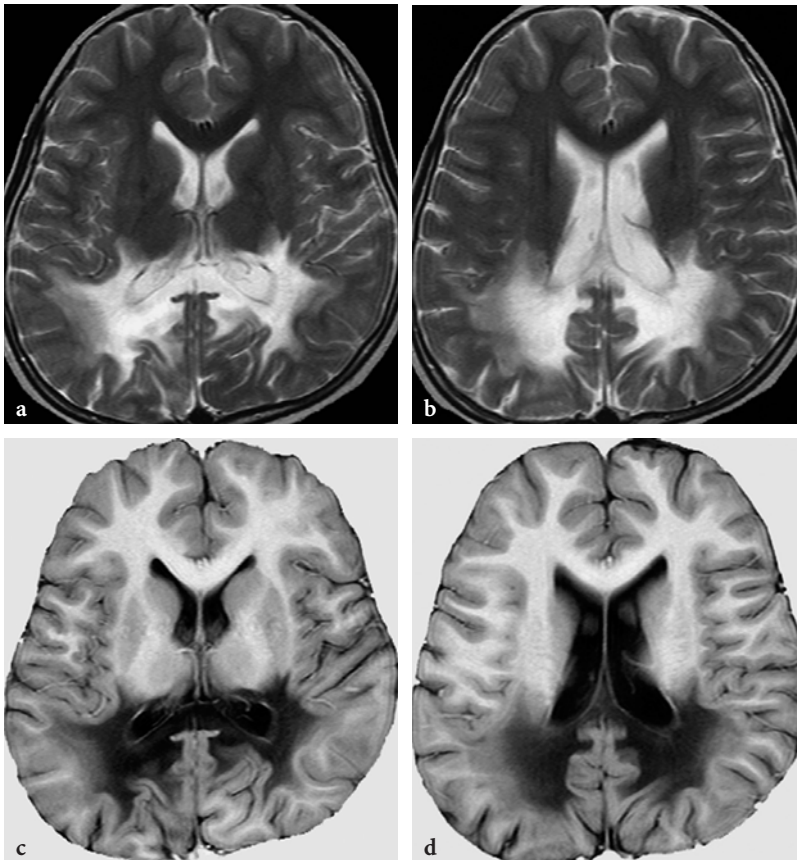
Conventional MR imaging findings in a 12-year-old male patient with X-linked adrenoleukodystrophy. a, b Axial T2-weighted fast spin-echo images. Symmetrical bilateral white matter lesions involving the parieto-occipital regions exhibiting a centrifugal progression pattern. The signal abnormalities extend to the posterior parts of internal, external, and extreme capsules, as well as the splenium of corpus callosum and postero-lateral parts of the thalami. This pattern indicates an additional postero-anterior gradient. c, d Axial T1-weighted inversion recovery images. The subcortical U-fibers are still spared in some, and already involved in other areas around the lesions
